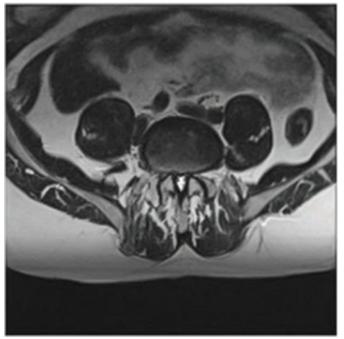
(a-c) MRI scans
